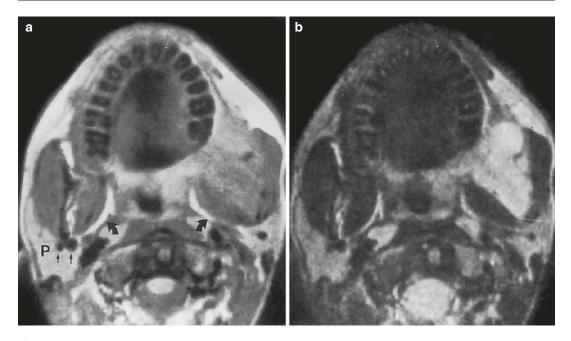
Myxofibroma of the jaws in a 16-year-old boy. (a) Axial spin-echo proton density-weighted MR image. (b) Axial spin-echo T2-weighted MR image. Expansive lesion at the left ascending ramus of the mandible is seen. On the proton density-weighted image, the myxofibroma has increased signal intensity compared with the pterygoid and masseter muscles. The T2-weighted image
